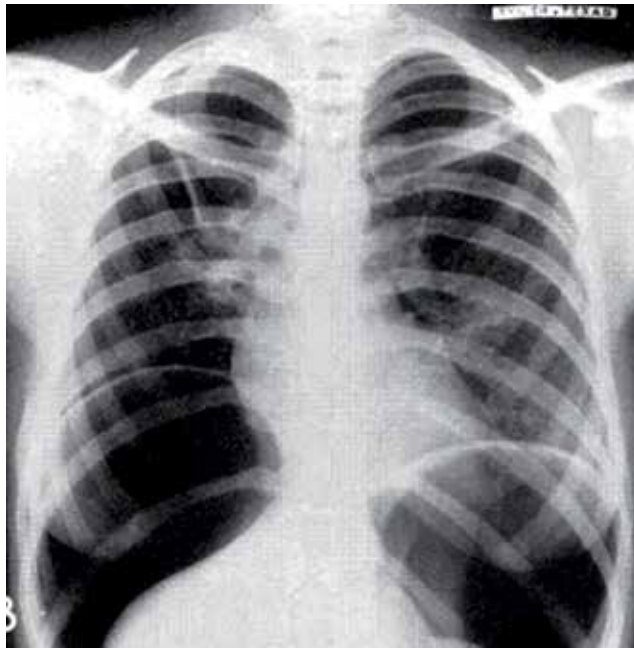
Pneumoperitoneum X-ray image.
